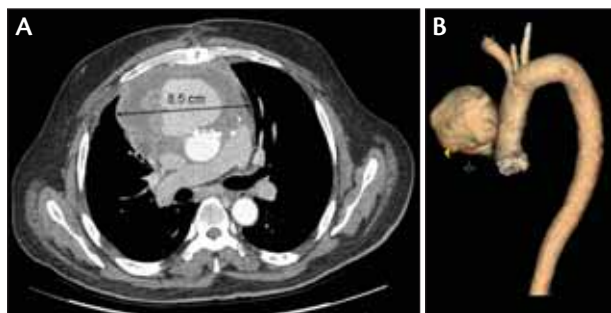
A mycotic ascending aortic pseudoaneurysm that recurred after patch repair of the small defect found at the time of surgery (A). Three-dimensional reconstruction of the CT angiography (B).
